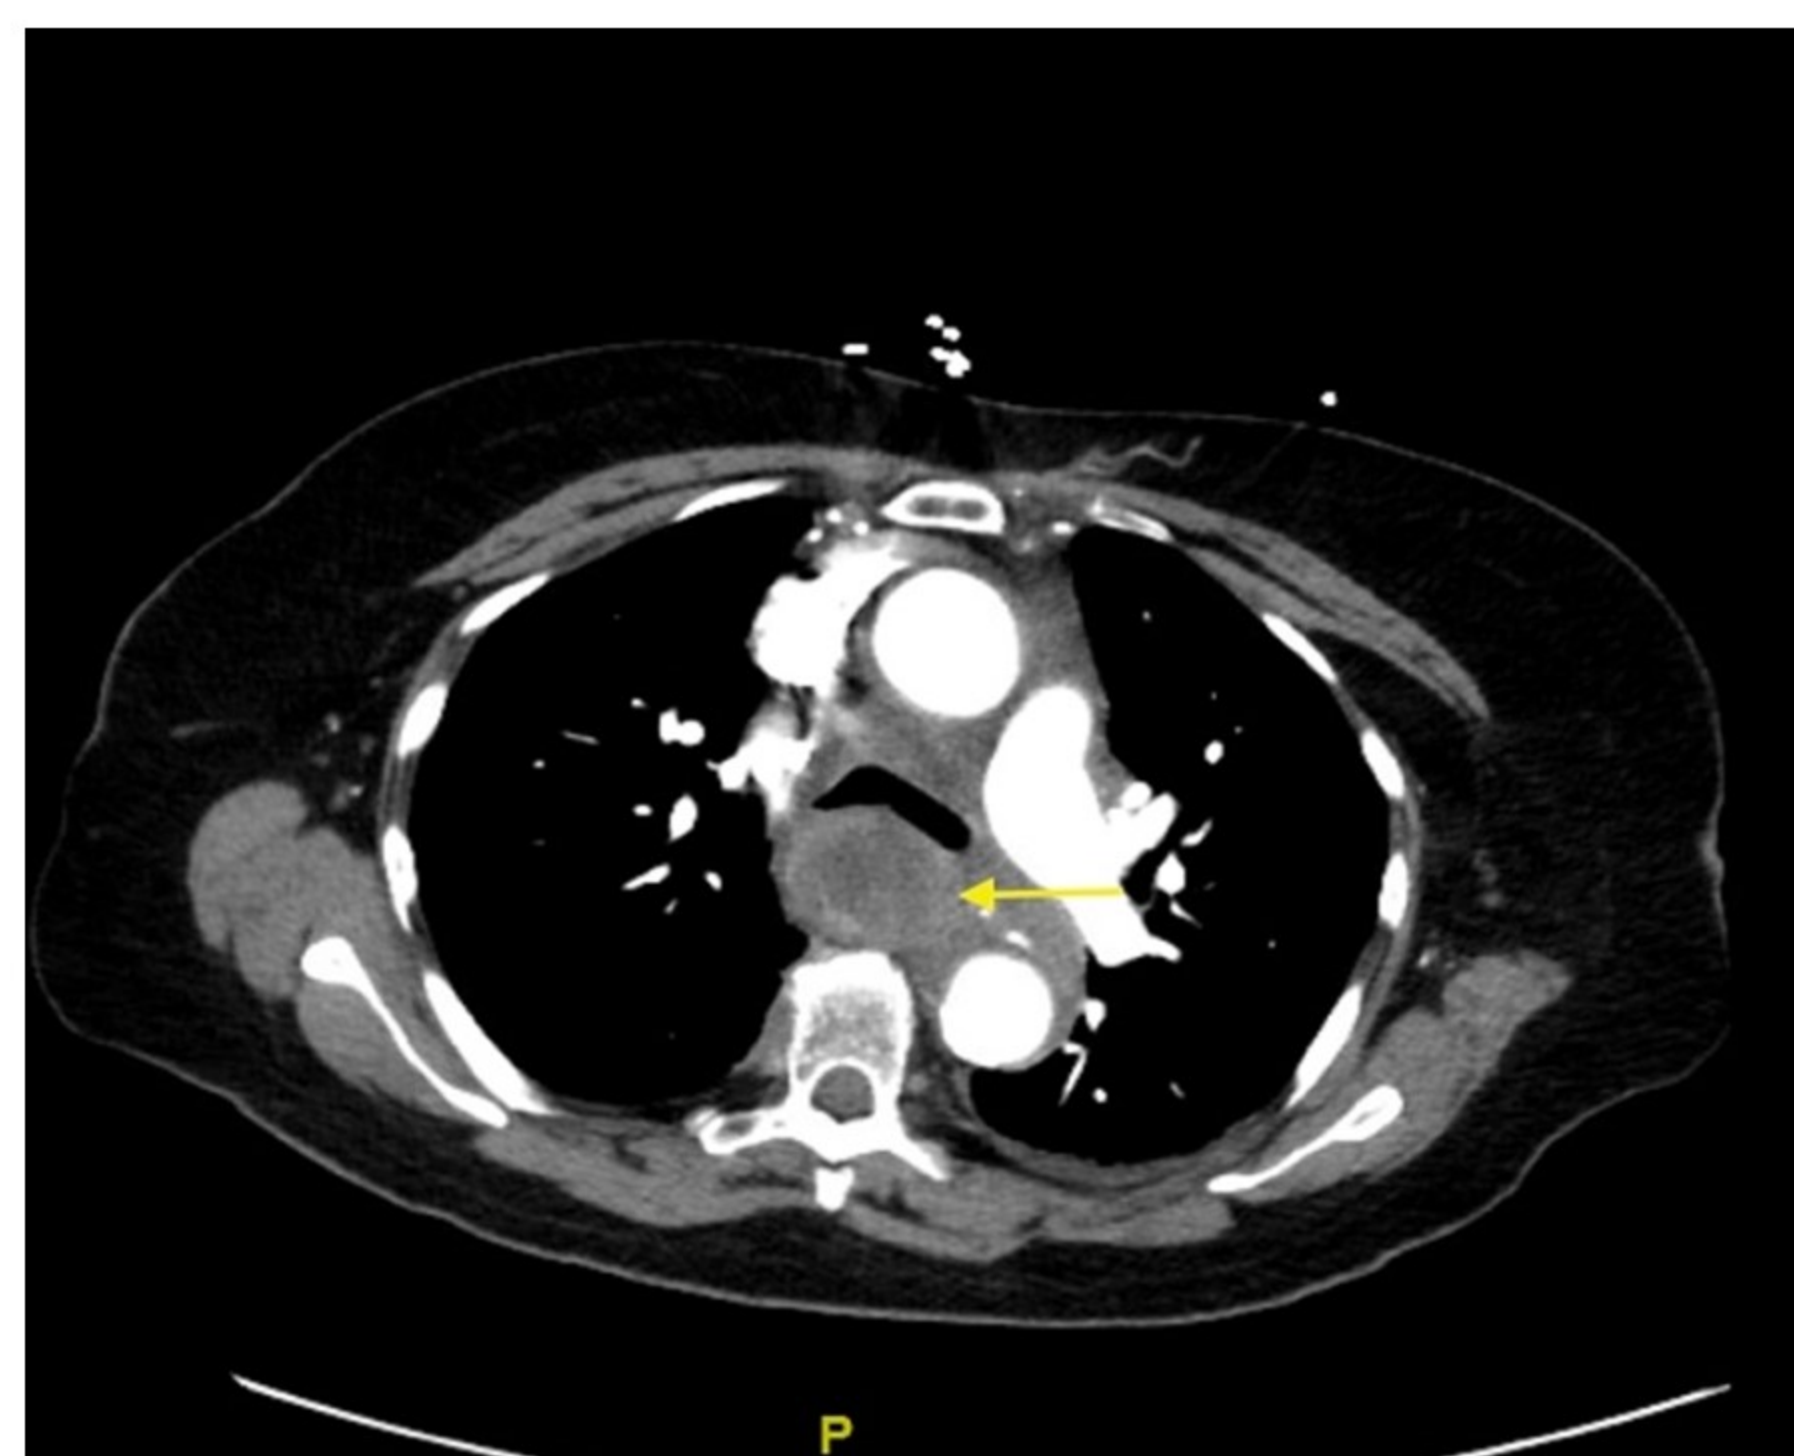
CT Chest with mediastinal mass causing dysphagia.
